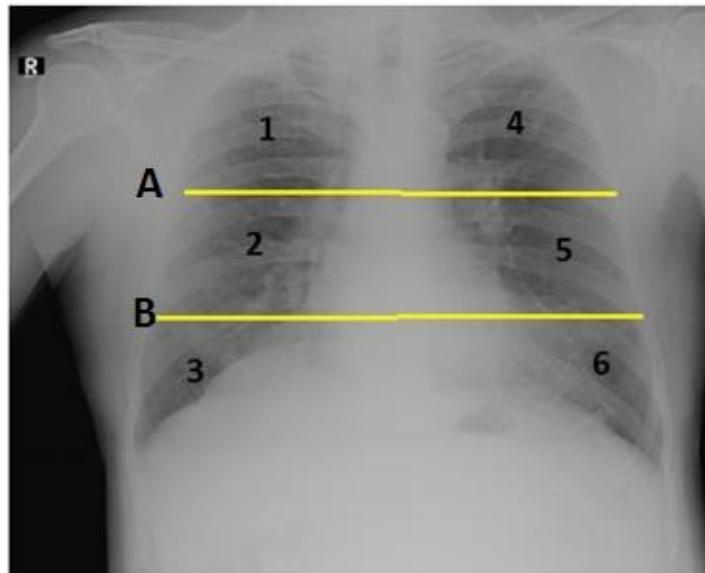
Chest x-ray showing scoring system
